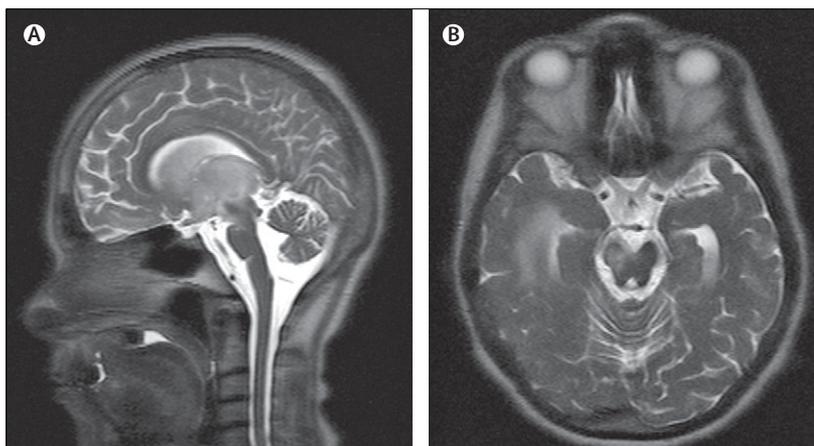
MRI scans of a patient with ophthalmoparesis and hemisensory loss due to neuro-Behçet's disease (A) T₂-weighted sagittal MRI showing an inflammatory mass arising from the diencephalon. (B) T₂-weighted axial MRI after recovery. Evidence for residual lesion is shown, but there is also atrophy of the midbrain and cerebellum.
